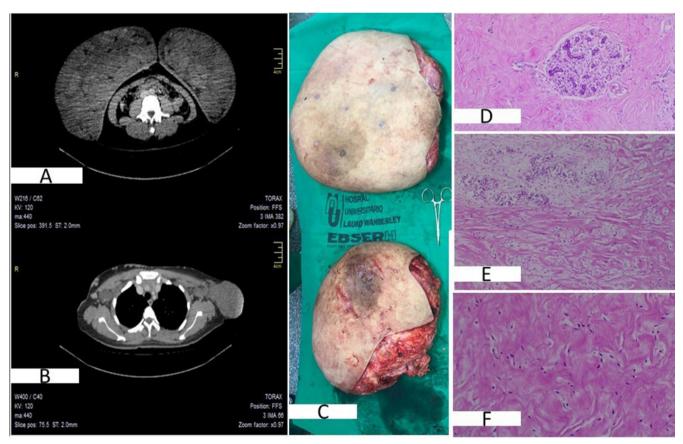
(A) Chest computed tomography shows a volumetric increase in the breasts due to multiple confluent nodular formations, predominantly retroglandular; (B) chest computed tomography highlighting the presence of multiple lymph node enlargements in axillary chains and the presence of the accessory breast on the left; (C) surgical parts of the direct and left breast (top to bottom); (D) anatomopathological showing stromal pseudoangiomatous hyperplasia, nodular and diffuse forms; (E) lymph nodes with reactive lymphoid hyperplasia; (F) absence of signs of malignancies.
